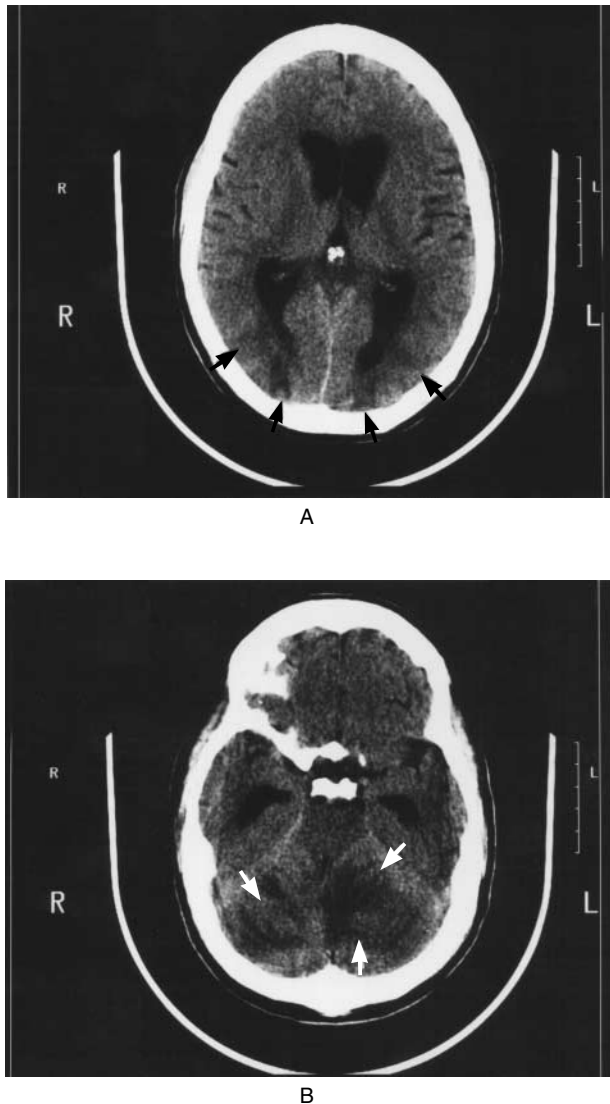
CT Scans of Patient 12.
